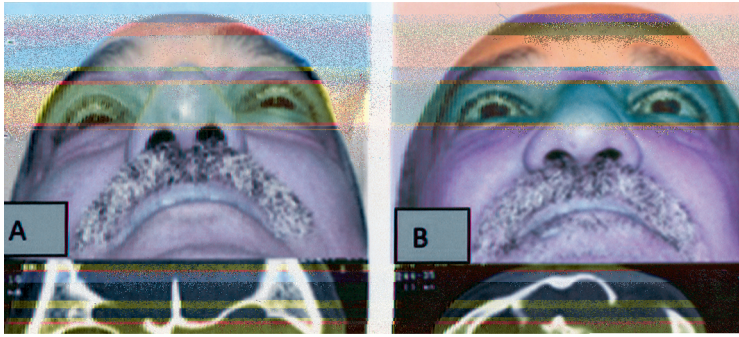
54-year-old patient with mucocoele following old frontal sinus fracture that was treated conservatively and underwent twice unsuccessful endoscopic frontal sinusotomy to drain it a few years later. (A) Preoperative worm's eye view demonstrating left sided proptosis. (B) Post-operative worm's eye view demonstrating correction of left eye proptosis. (C,D) CT coronal and axial cuts showing destruction of the frontal sinus walls and intra-orbital extension of the mucocoele (E,F,G) show steps of sinus duct obliteration. (H) The wall of mucocoele being peeled of the inner walls of the sinus that are seen eroded. (I) final result after recapping and fixation of the cranial vault.
